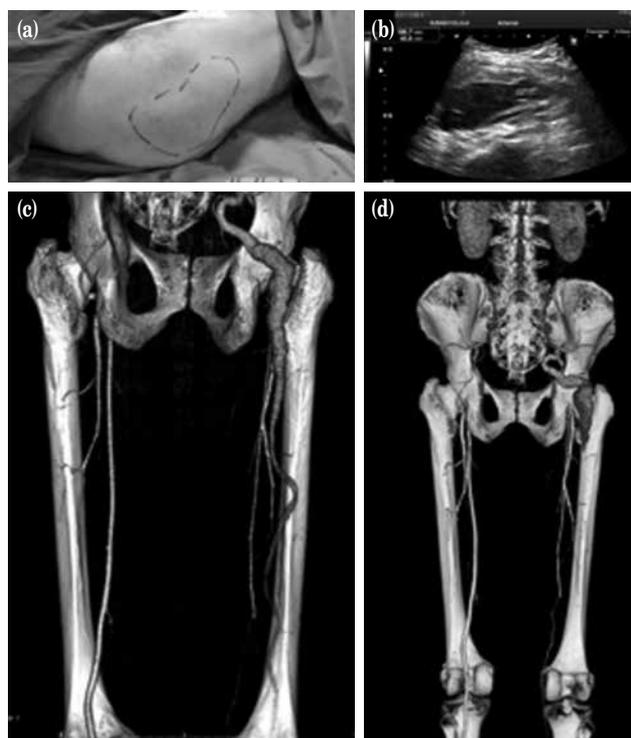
Physical examination, superficial and Doppler ultrasonography and computed tomography showed a persistent sciatic artery. (a) The pulsatile mass on the patient's right hip (dotted line). (b) Doppler ultrasonography revealed a large mass of 100.7×43.8 mm originating from a vascular structure. (c) Three-dimensional reconstruction of the computed tomography images obtained three years ago demonstrated a complete persistent sciatic artery with incompletely developed femoral arteries and an aneurysm 66 mm in diameter at the posterior aspect of the major trochanter of the femur (posterior view). (d) Three-dimensional reconstruction of the computed tomography images demonstrated a complete occlusion of the distal segment of the persistent sciatic artery.
